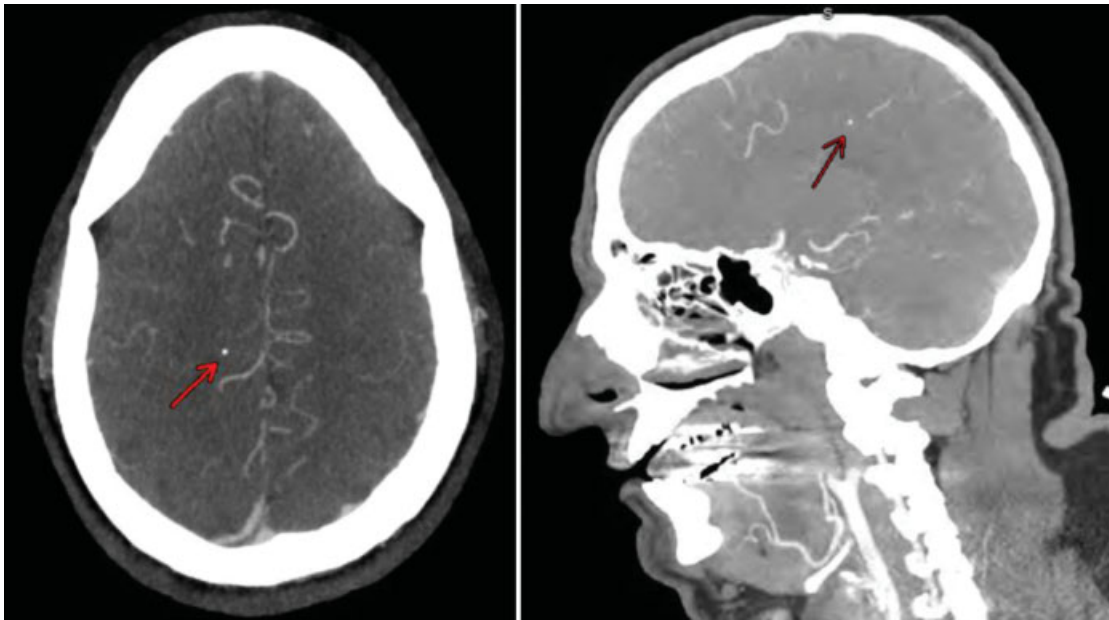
Computed tomography angiography (CTA) scan demonstrating the intracerebral metallic foreign body.
